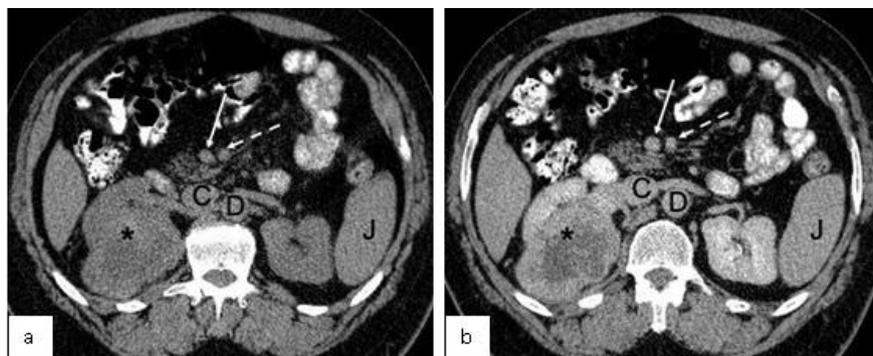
Non-contrast (a) and contrast-enhanced (b) CT images of the abdomen of a 52-year-old male show a right-sided renal cell carcinoma (black asterisk). The mass arises from the medial aspect of the right kidney and shows heterogeneous and relatively reduced enhancement compared to the native kidney. The inferior vena cava (C), abdominal aorta (D) and spleen (J) are also visible in this image. Solid and dashed white arrows point to the SMV and SMA, respectively
